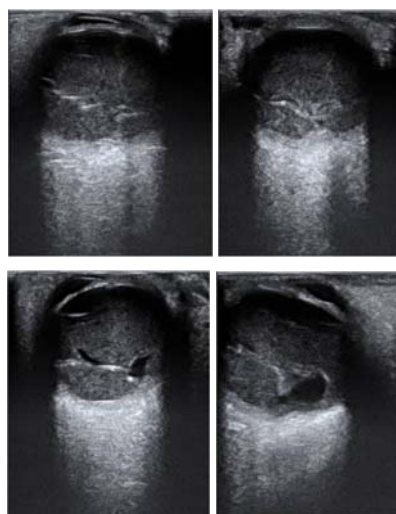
(A-D) Choroidal Melanoma. B-scan ultrasound: Shows a dome-shaped large lobulated solid mass posteriorly, with posterior acoustic shadowing and choroidal excavation.
